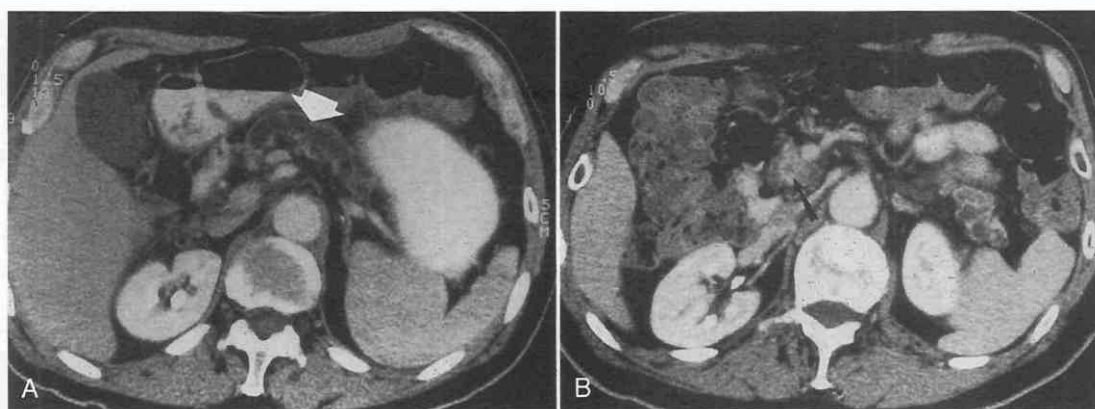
A, CT scan of a patient with chronic pain, which shows severe dilatation of the pancreatic duct. The diameter of the duct is more than 0.5 the diameter of the gland (arrow). The duct is somewhat tortuous, which some authors suggest may be consistent with pancreatitis. B, A lower section on CT scan shows a small high-density mass (arrow) within the fat density gland, which proved to be cancer at surgery.
